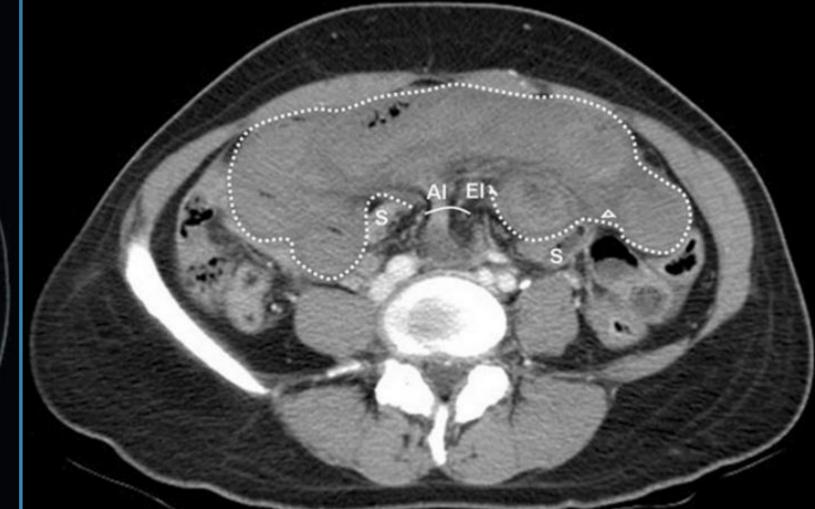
A 47-year-old woman presented with epigastric pain with nausea and vomiting due to strangulated IH, intersigmoid type. IH into lesser sac through foramen of Winslow. MDCT in Abdominal CT demonstrates a cluster of dilated small bowel axial section, revealing the clustered small-bowel loops loops (within dotted line) in the lower abdomen, with displacement of the sigmoid colon (S). The bowel wall of the herniated small bowel loops shows thickened, decreased enhancement, and mesenteric fluid accumulation (hollow arrowhead). Note the narrowed afferent (AI) and efferent (EI) loops were passing through the sigmoid mesocolon defect (curved line).
